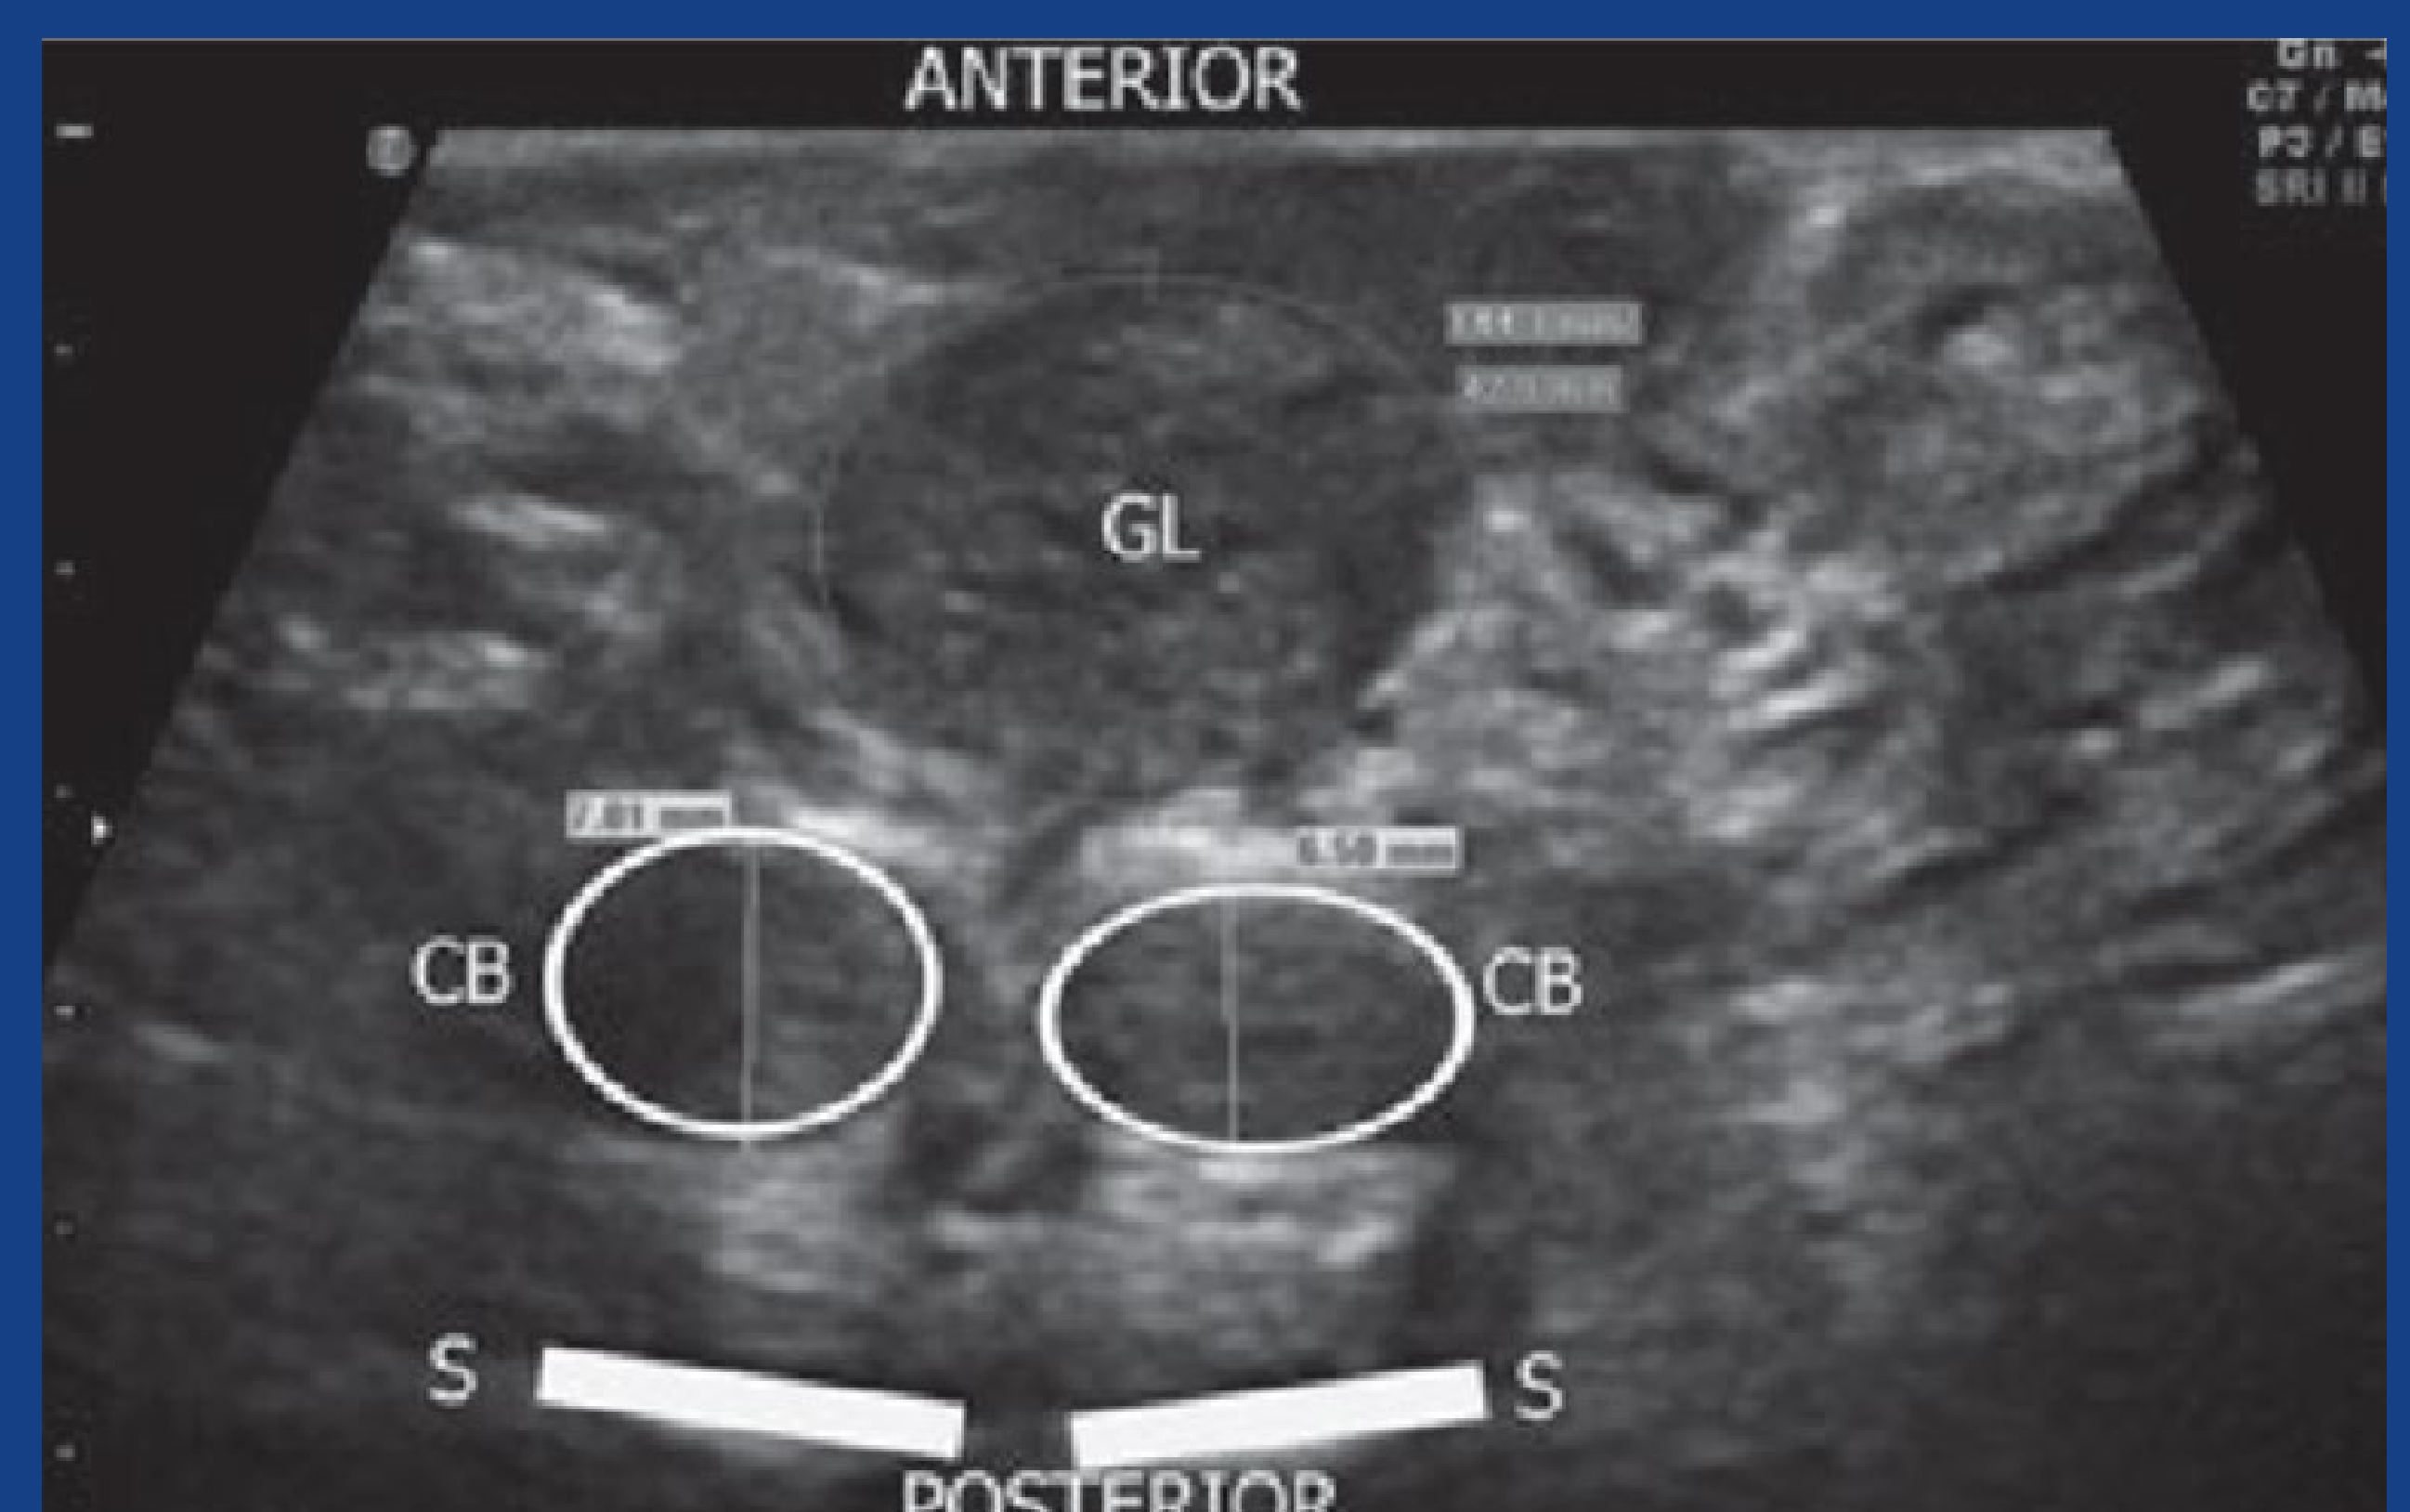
Sonographic features of the clitoris. Cross-section of the clitoral bodies and the glans. GL = glans; CB = clitoral body; S = Symphysis (5)
